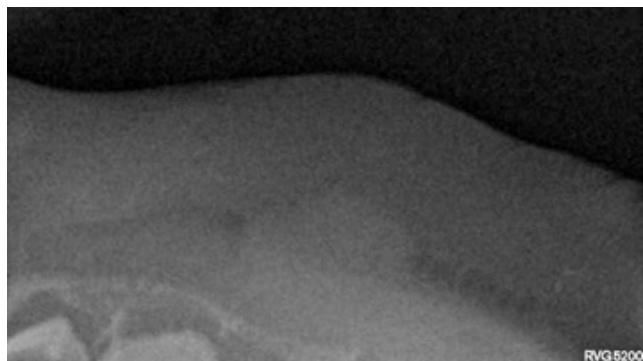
Radiographic (RVG) follow-up done after one month.
